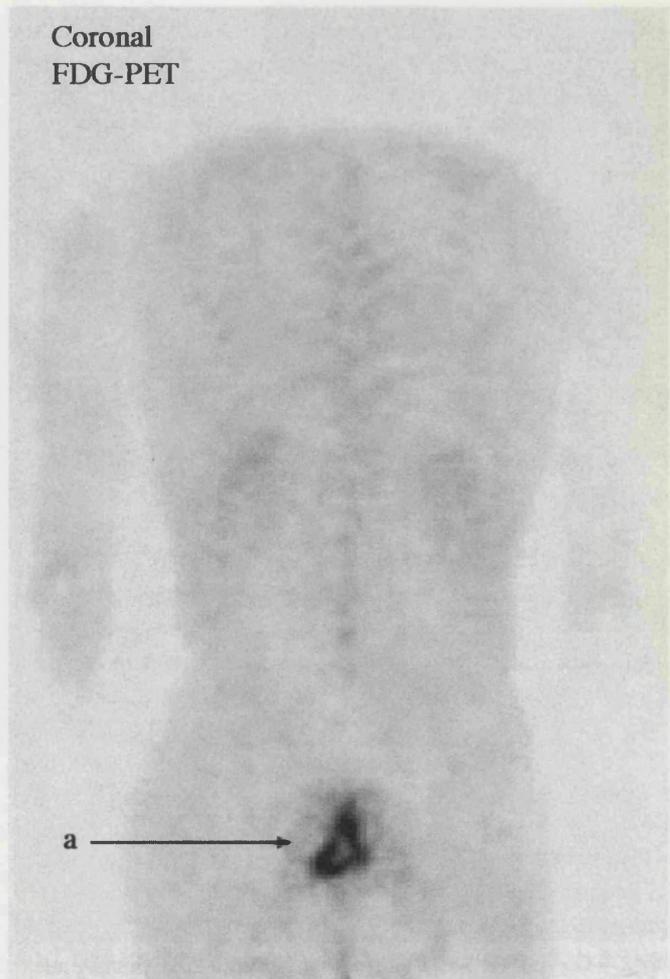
Coronal FDG-PET in a patient who underwent anterior resection of the rectum for adenocarcinoma. FDG uptake was demonstrated behind the bladder (a), but flexible sigmoidoscopy and biopsy revealed inflammatory tissue only.
